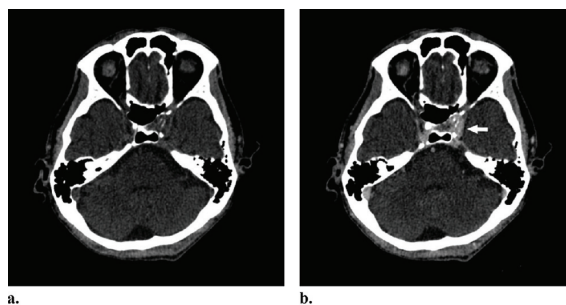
Noncontrast (a) and contrast-enhanced (b), axial CT scan of the brain at the level of cavernous sinus shows a homogeneous enhancing lesion at the left cavernous sinus causing bulging of the posterior wall of the left sphenoid sinus (solid white arrow).
